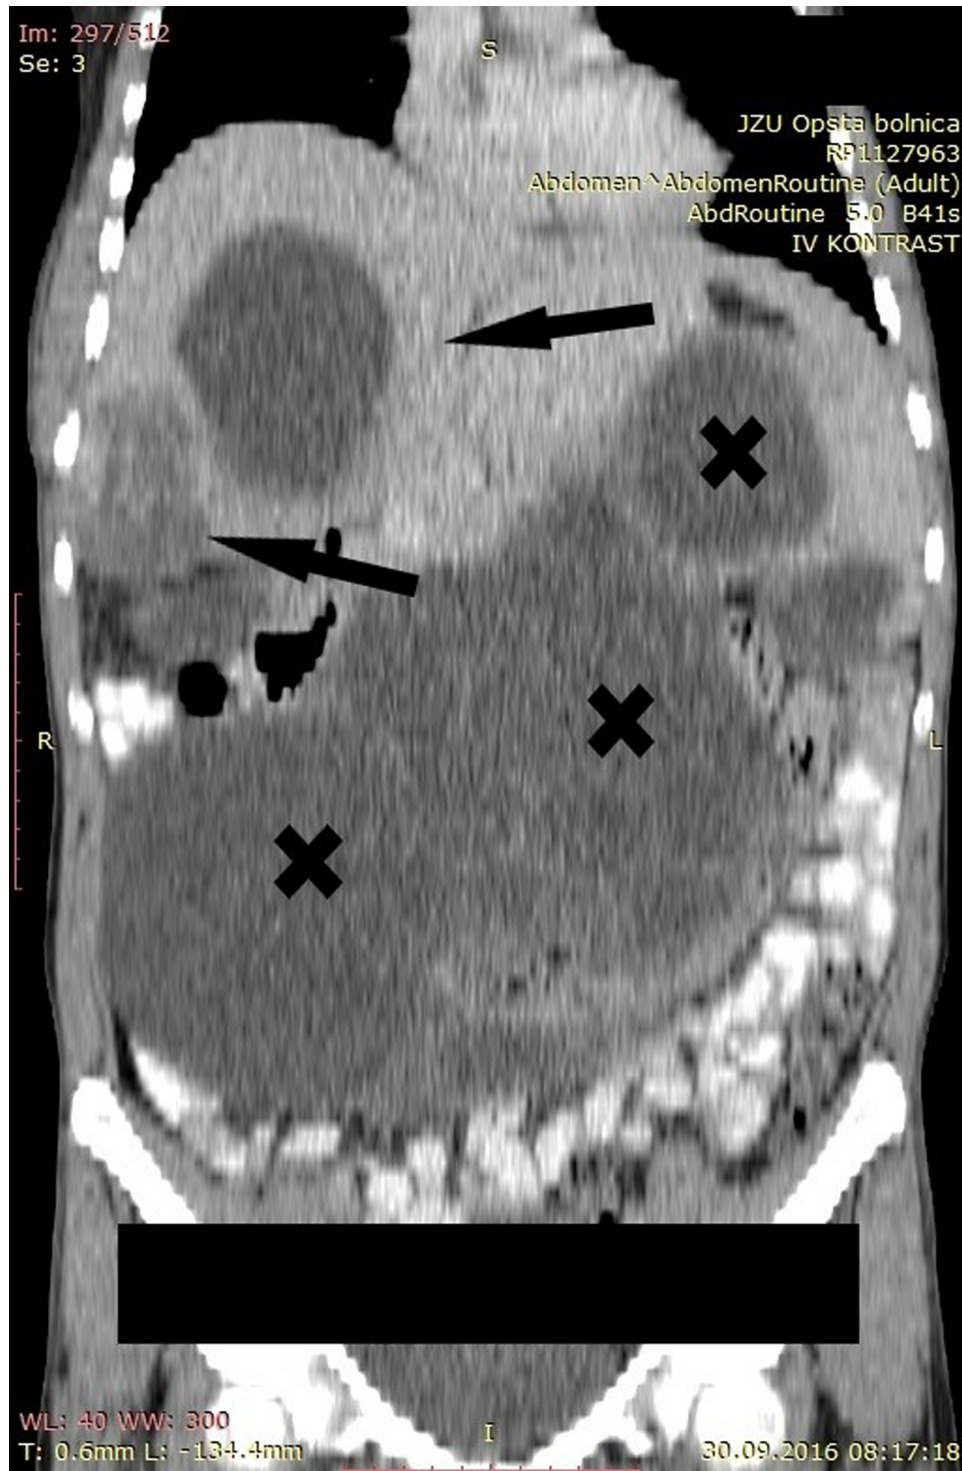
Coronal CT scan of the abdomen showing large multiple intra-abdominal cysts (crosses) and two cysts in the liver (arrows).
